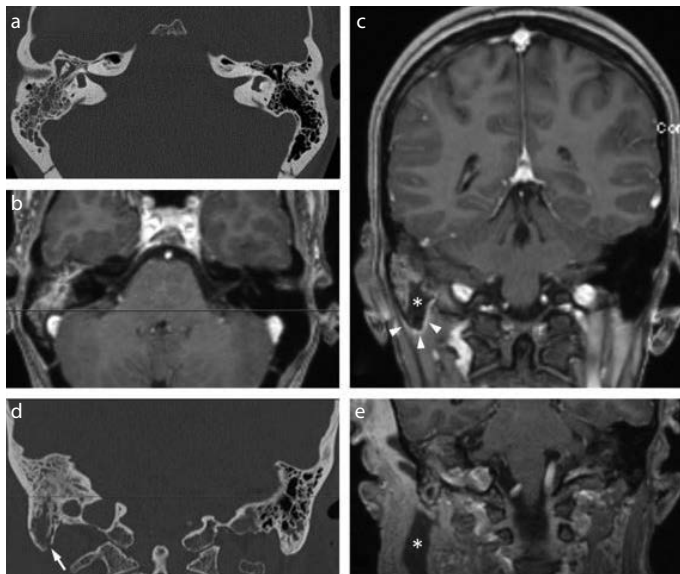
a-e. CT and MRI images of a patient with AM (a-c) and a patient with AMc (d, e). A normal-size mastoid cavity filled with inflammatory secretions and soft tissue is seen in the CT of a patient with AM (a). MRI gives a better overview of the soft tissue component, showing an intense enhancement of the intramastoid-inflamed mucosa or granulation tissue (b), as well as a necrotic unenhanced area at the tip of the mastoid process (asterisk in c) and periosteal enhancement compatible with periostitis (arrowheads in c). In an AMc patient, a sclerotic mastoid cavity is seen in CT with osteolysis and a bony cortical defect at the tip of the mastoid (arrow in d). MRI reveals a large Bezold's abscess (asterisk in e) in the soft tissues of the neck.
